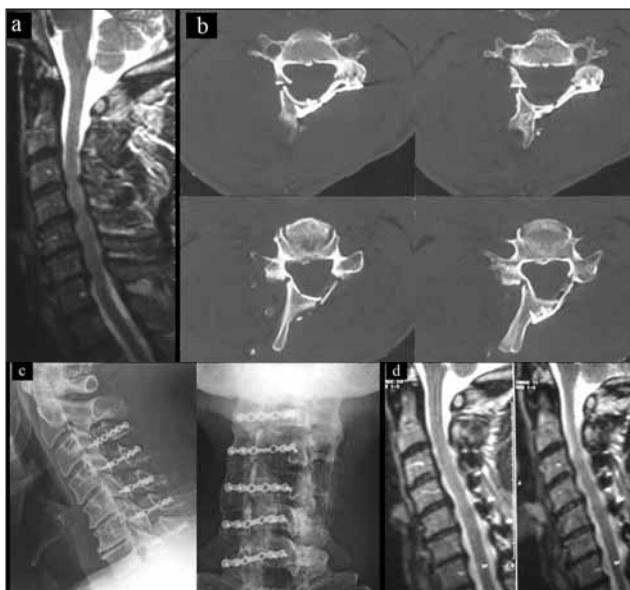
(A) Preoperative MRI of a 58-year-old man, demonstrating five-level cervical stenosis with C5-6 and C6-7 right foraminal stenosis. (B) Sagittal CT (computed tomography) after open-door laminoplasty using allograft and mini-plates. (C) Postoperative radiography of the cervical vertebral column, carried out antero-posteriorly and laterally, shows allografts and mini-plates with good alignment. (D) Postoperative MRI shows an enlarged cervical spinal canal.
